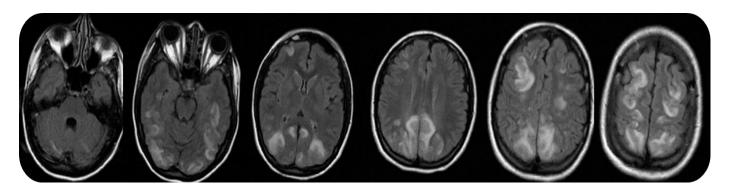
FLAIR sequence showing bilateral high-signal foci in the cerebellum, basal ganglia, and occipital, parietal, frontal, and temporal lobes
